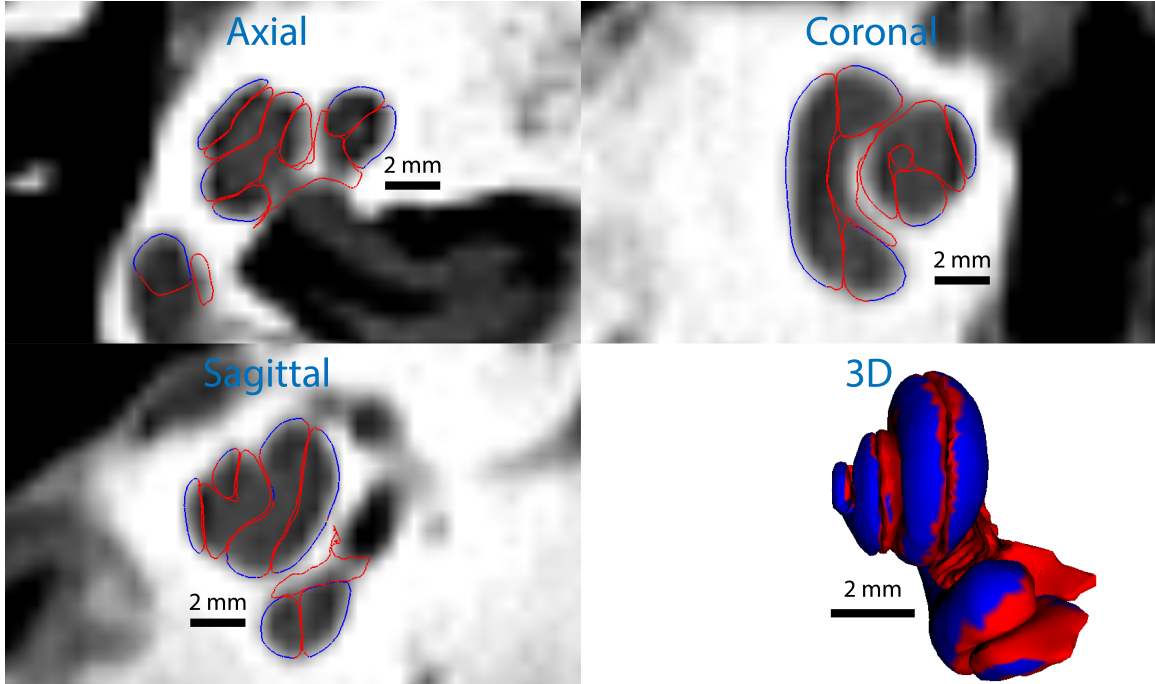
Example ASM segmentation with labeling of exterior (blue) vs. interior (red) points of the cochlea. Note that the exterior points generally correspond to stronger image gradients in the corresponding CT.
